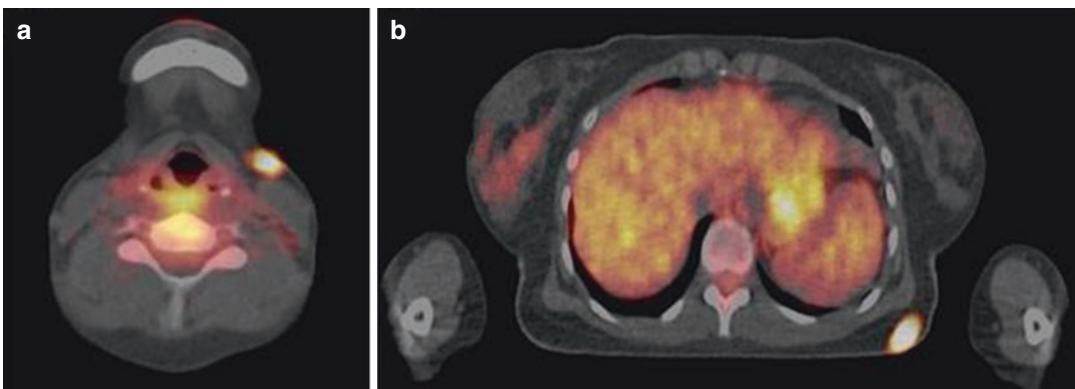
(a) Fused PET-CT image: subtly enlarged hypermetabolic submandibular lymph node in metastatic melanoma, (b) Fused PET-CT image: hypermetabolic melanoma deposit at the subcutaneous fat
